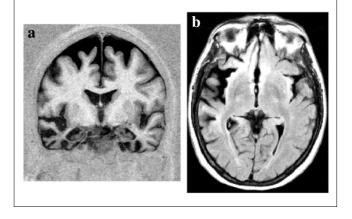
Patient with Alzheimer's dementia and severe, asymmetric atrophy of the temporal lobes. a Coronal T1-IR image. b Axial T2 FLAIR image
